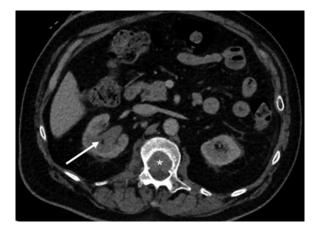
Portovenous phase CT showed abnormal soft tissue expanding the right renal pelvis (arrow). There is extensive bone destruction within the thoracic vertebral body at the same level with an extradural mass (*) causing imminent cord compression.
